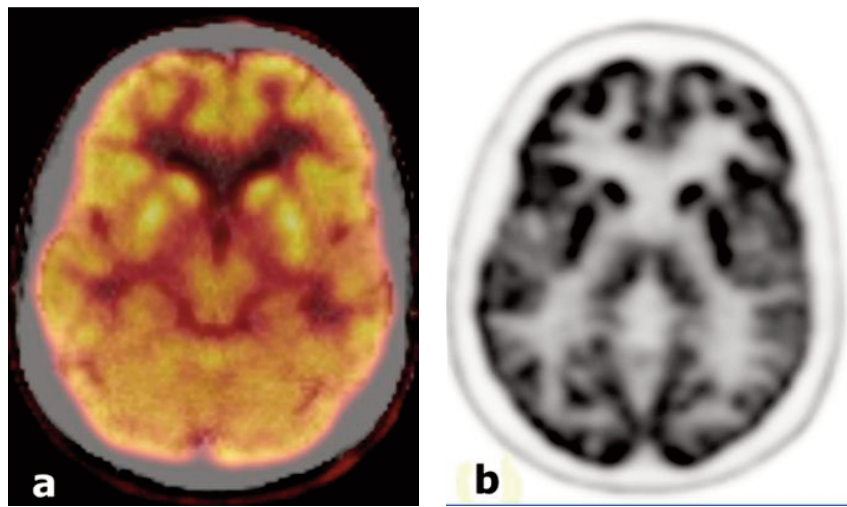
Positron emission tomography CT (PET-CT) exploration for a patient without a well defined epileptic zone ;main sequences (a,b) are showed in this figure.
